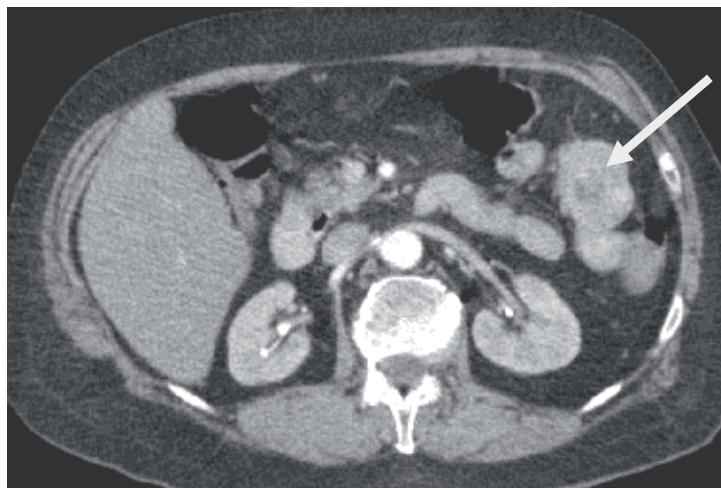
CT findings of small bowel stromal tumor: a 43/28/28 mm well-defined mass with central necrosis in the proximal jejunum (image courtesy of D. Negru, MD)
